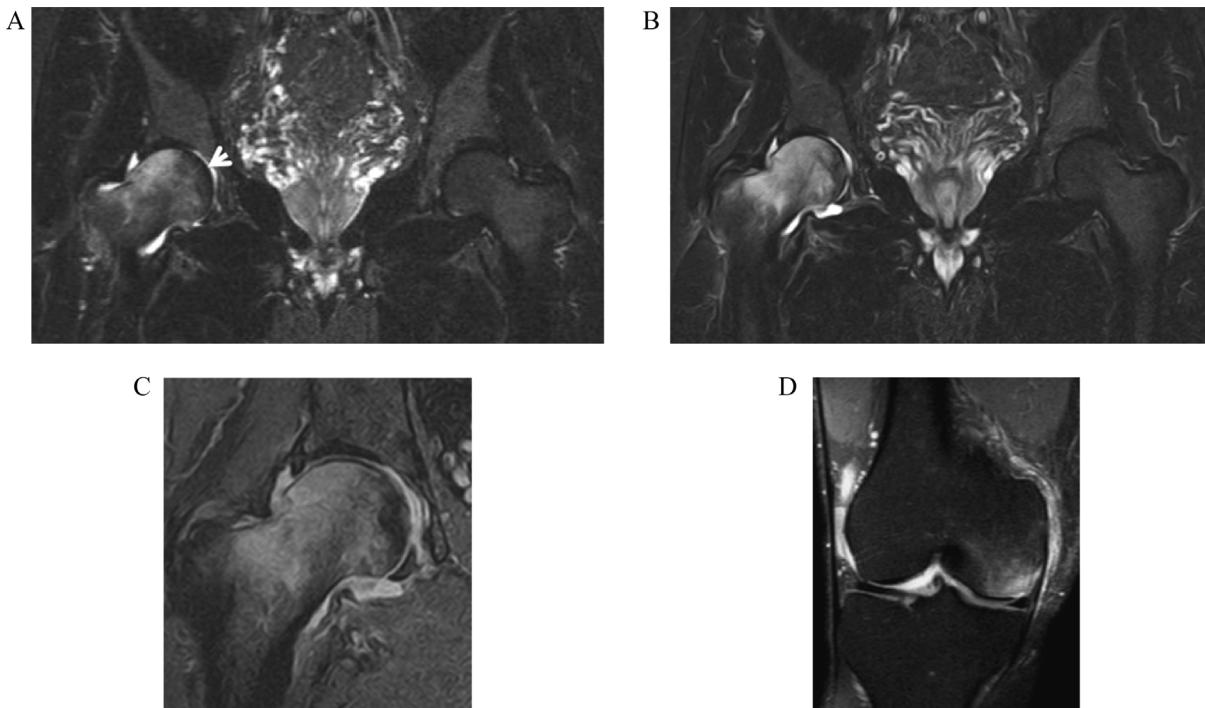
A 57-year-old male patient with right hip joint pain and a diagnosis of regional migratory osteoporosis syndrome. The coronal STIR MR image (A) obtained at 13/3/13 shows mild bone marrow edema and medial bone marrow sparing (white arrow). Follow-up MR imaging examination was obtained at 10/4/13 with the patient reporting symptom deterioration. The coronal STIR (B) and high resolution fat suppressed PD-w images (C), show expansion of the bone marrow edema and reduction of the bone marrow sparing. At November 2012 prior to the hip MR imaging studies, the patient reported knee pain and the coronal STIR image (D) showed medial femoral condyle bone marrow edema.
